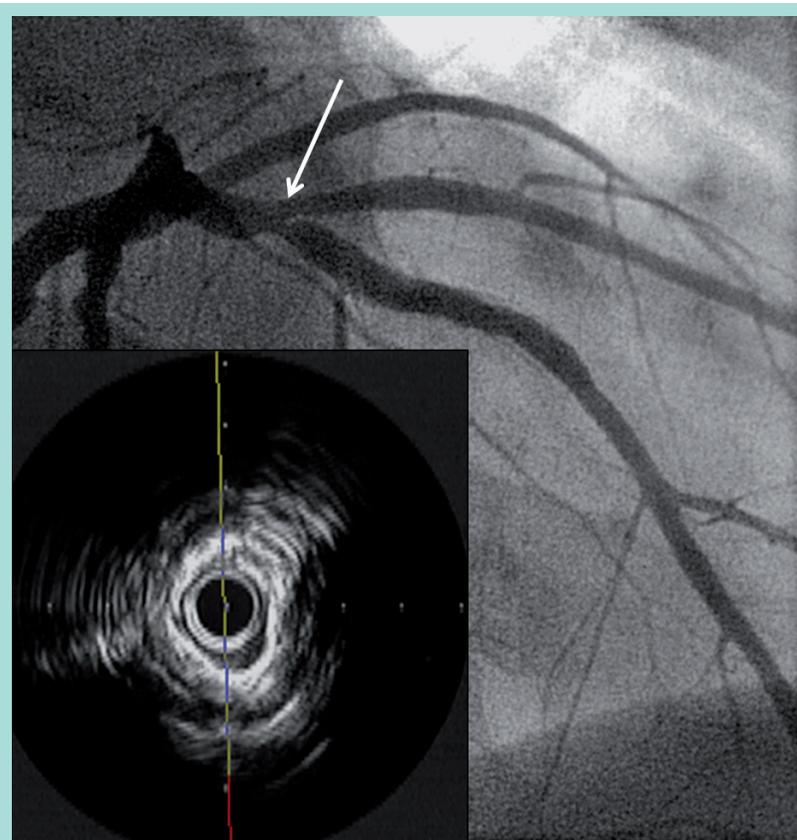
Angiogram of the left anterior descending artery showing the presence of a lesion right after the origin of a large diagonal branch. Ostium of the diagonal branch is indicated by an arrow. Intravascular ultrasound imaging of the diagonal branch showed extensive compromise of the ostium with unsuspected severe concentric calcium.
